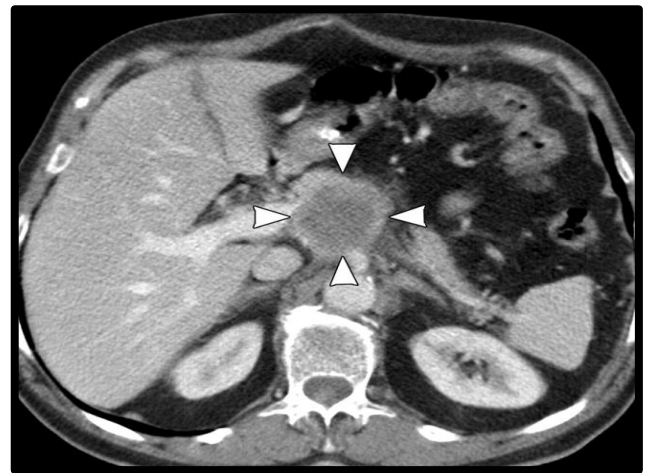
CT scan shows a tuberculous lymph node with the characteristic low-attenuation center and peripheral rim enhancement (arrowheads).
